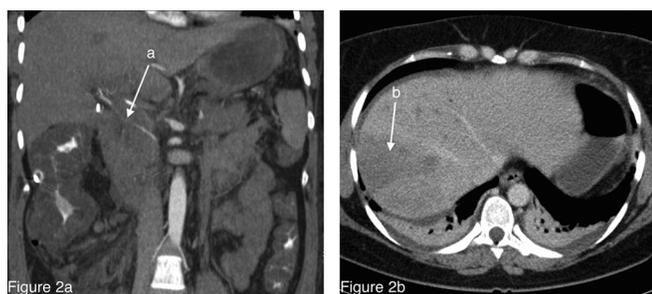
CT scan on postoperative day 1 (patient developed highly elevated liver enzymes [alanine aminotransferase 33 $\mu\text{kat/L}$, aspartate aminotransferase 44 $\mu\text{kat/L}$]). A. CT angiography, coronal reconstruction demonstrating thrombosis of the right liver artery (arrow a). B. Portal-venous phase showing liver infarction in segments 7/8 (arrow b).
